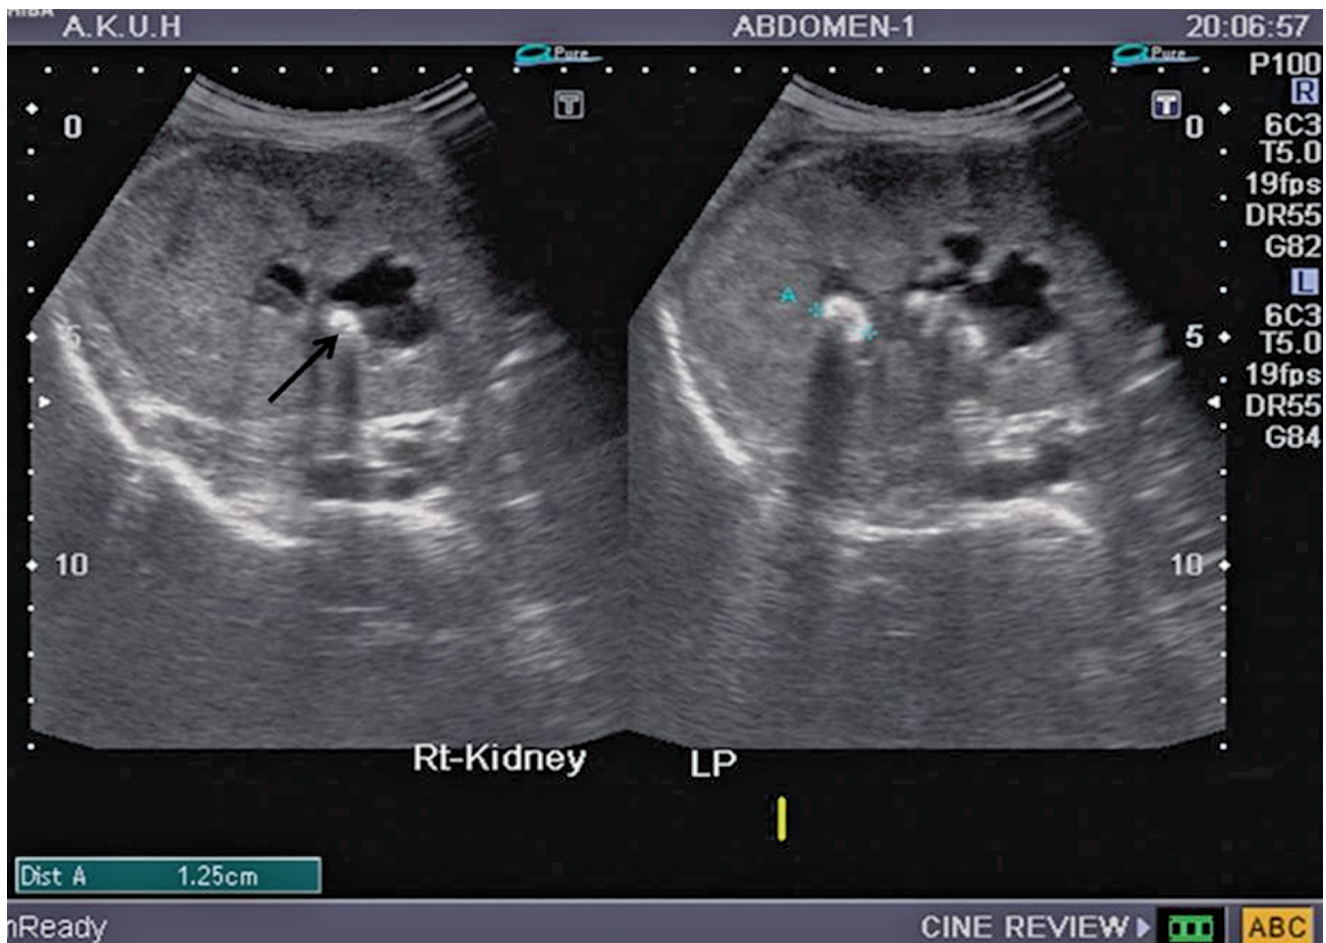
Ultrasound showing renal stones and pyelonephritis (arrow)
